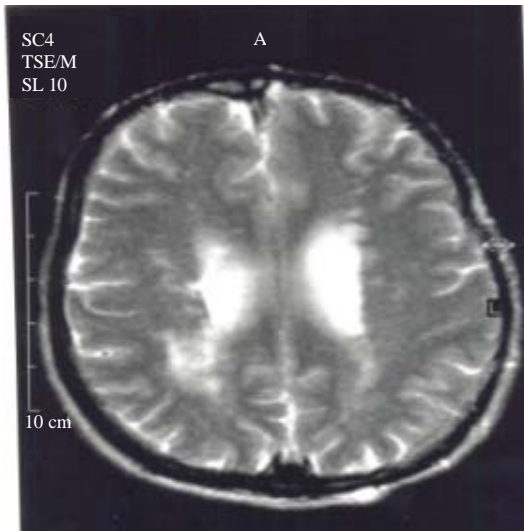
Axial MRI T2WI: bilateral periventricular MS plaques
